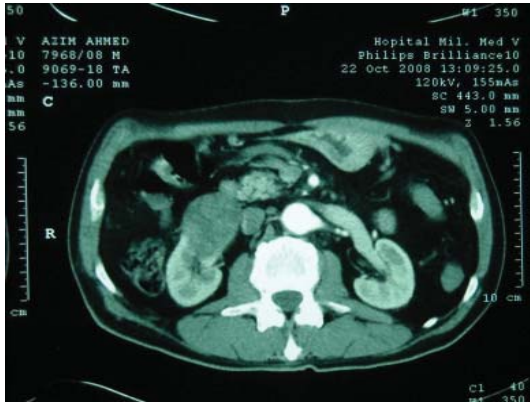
Abdominal computed tomography (CT) showing heterogeneous enhancing right renal mass.
